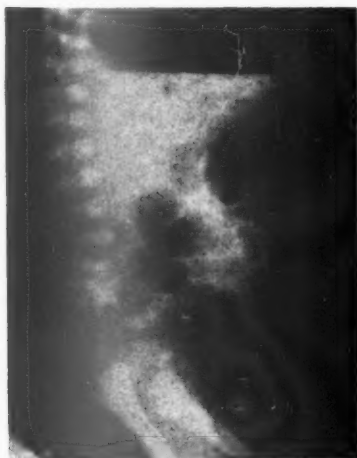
X-ray taken when the infant was nearly 3 weeks old and suffering from abdominal distension. The vertebrae are perfectly normal.
